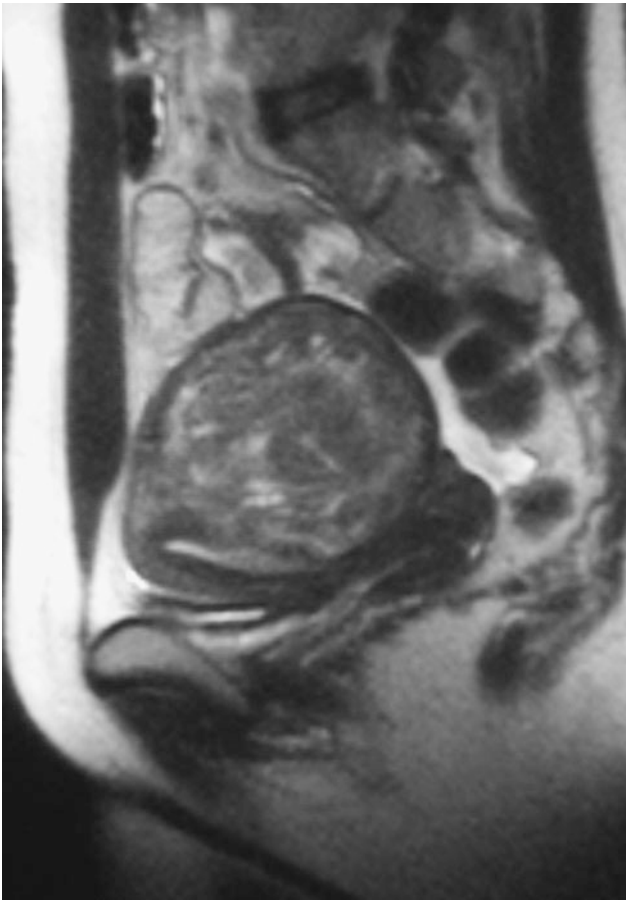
Typical fibroid location in a patient with heavy menstrual bleeding. Sagittal T2-weighted MR image of the pelvis in a patient with a transmural posterior wall fibroid with substantial compression of the endometrial cavity. Because of the distortion of the endometrial cavity, the fibroid is likely the cause
